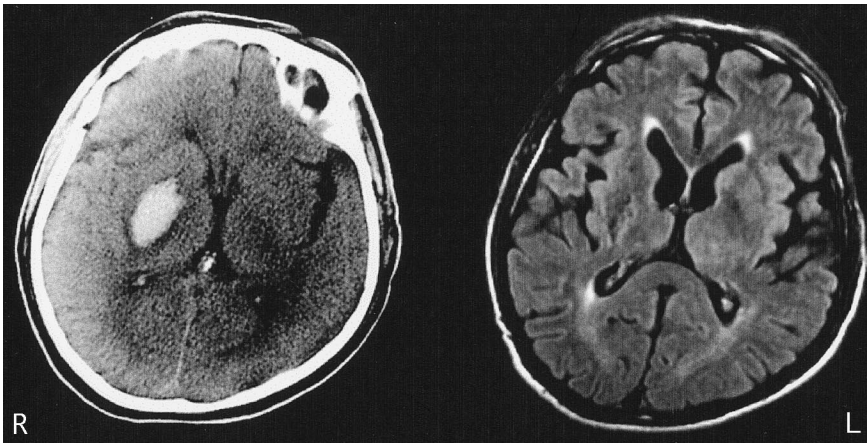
CT scan on the day of onset (left) and MRI 10 months after intracranial hemorrhage (right). A hematoma is visible in the right putamen with CT, which is also visible with MRI after stereotactic surgery.
